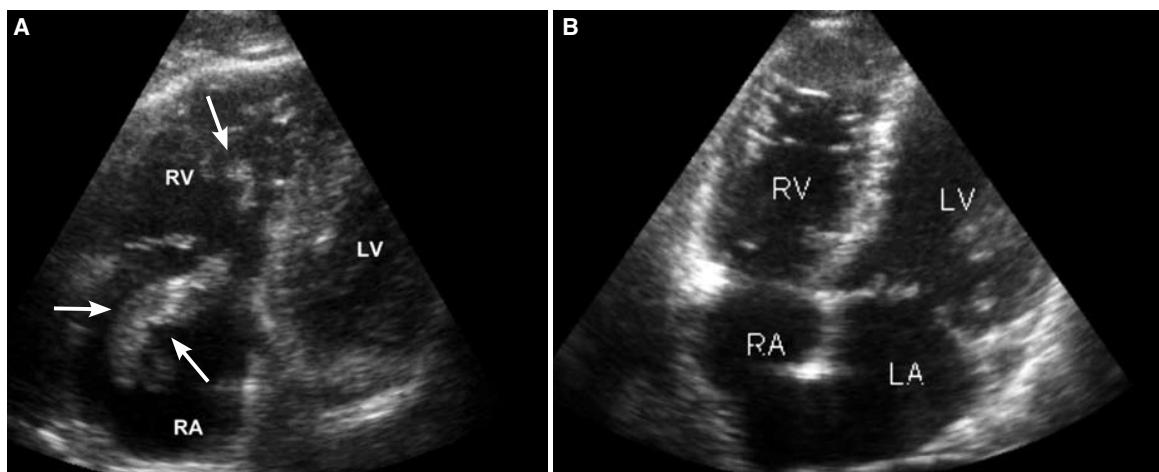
Transthoracic four-chamber views demonstrating (A) free-floating, worm-like thrombus (arrows) in the right heart, and (B) complete dissolution of the thrombus with normal sizes of the right ventricle and right atrium. RV: Right ventricle; LV: Left ventricle; RA: Right atrium; LA: Left atrium.
